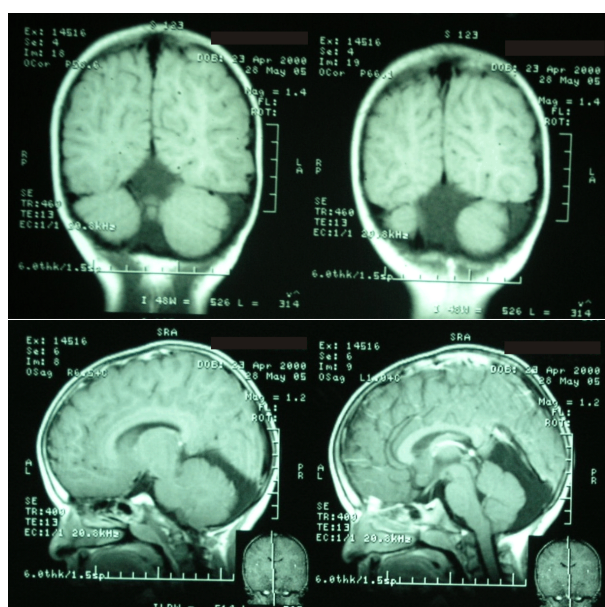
Dandy–Walker variant. Brain MRI: inferior vermician hypoplasia; asymmetry of cerebellar hemispheres, with hypoplasia of the left cerebellar hemisphere comparative to the right one; elevation of the cerebellar tentorium, with moderate dilation of the fourth ventricle.
